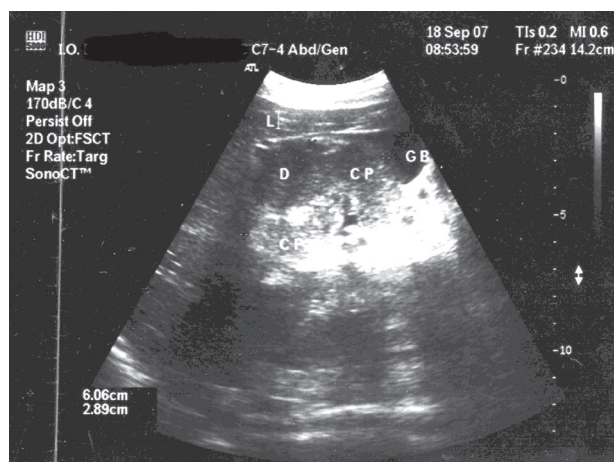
Ultrasonography image of partial annular pancreas; CP, body of pancreas; GB, gallbladder; D, duodenum; L, liver.
